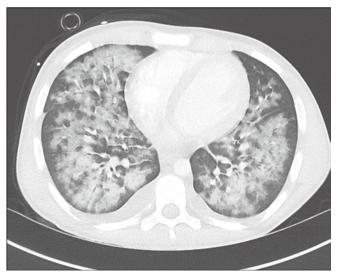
CT chest at presentation demonstrating findings consistent with diffuse alveolar haemorrhage
